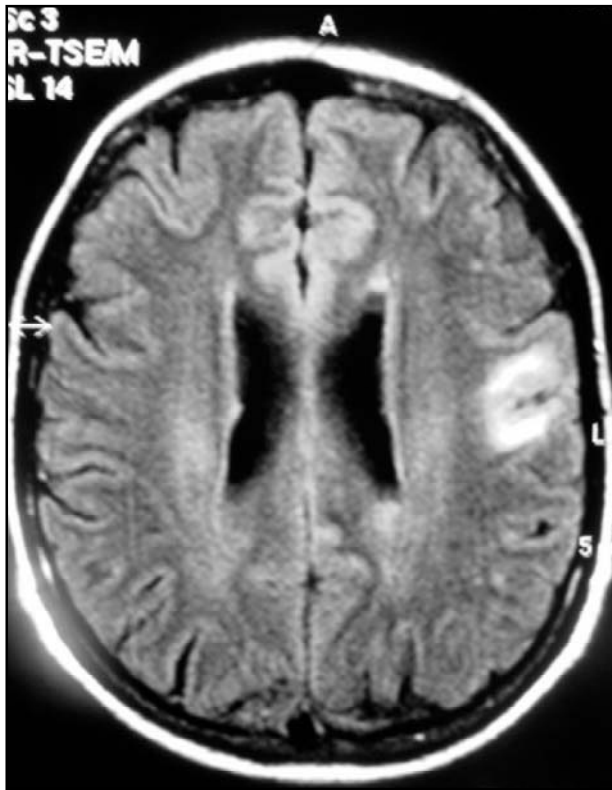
FLAIR axial image with hypersignal in the left parietal area.
